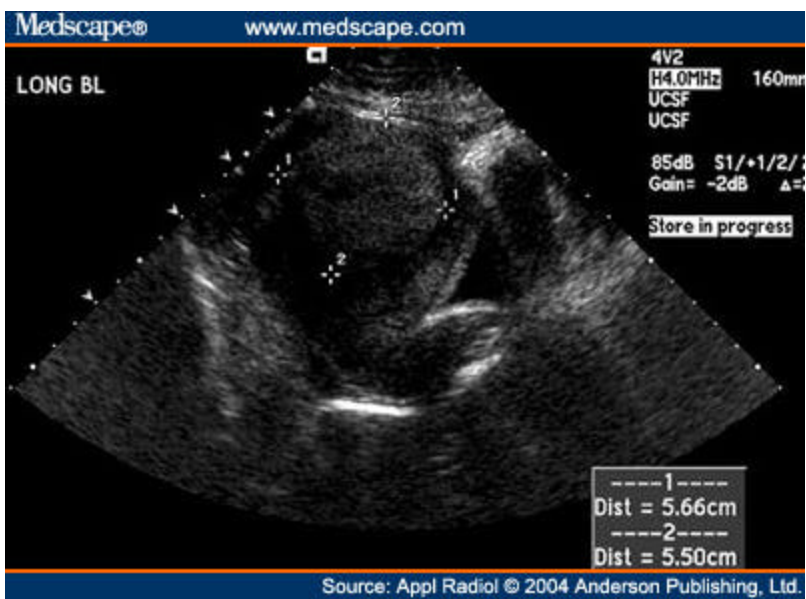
Submucosal fibroid: (A) gray-scale sagittal transvaginal ultrasound of the uterus with a 5.66- x 5.50-cm fibroid. (B) Similar view as in Figure 4A with power Doppler shows flow within the fibroid. The fibroid is centered in the myometrium and distorts the endometrial cavity. (C) A sagittal T2- weighted MRI in the same patient reveals the submucosal nature of the fibroid more clearly, with a significant portion bulging into the endometrial cavity.
